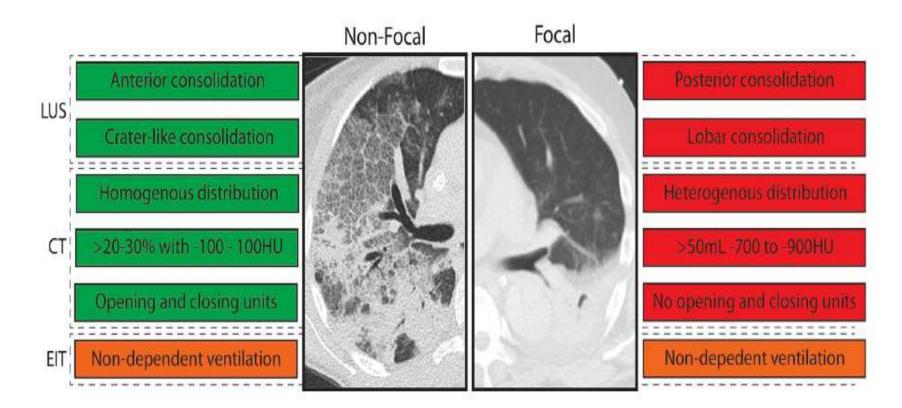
Imaging abnormalities that predicted response to recruitment maneuvers (RM) stratified per morphology. LUS, lung ultrasound; EIT, electrical impedance tomography; CT, computed tomography; HU, Houndsfield units; green, imaging abnormality in line with responder to RM; red, imaging abnormality in line with non-responder to RM; orange, imaging abnormality in line with responder with high uncertainty. Text boxes on the left: consistent with non-focal morphology. Text boxes on the right: consistent with focal morphology.
